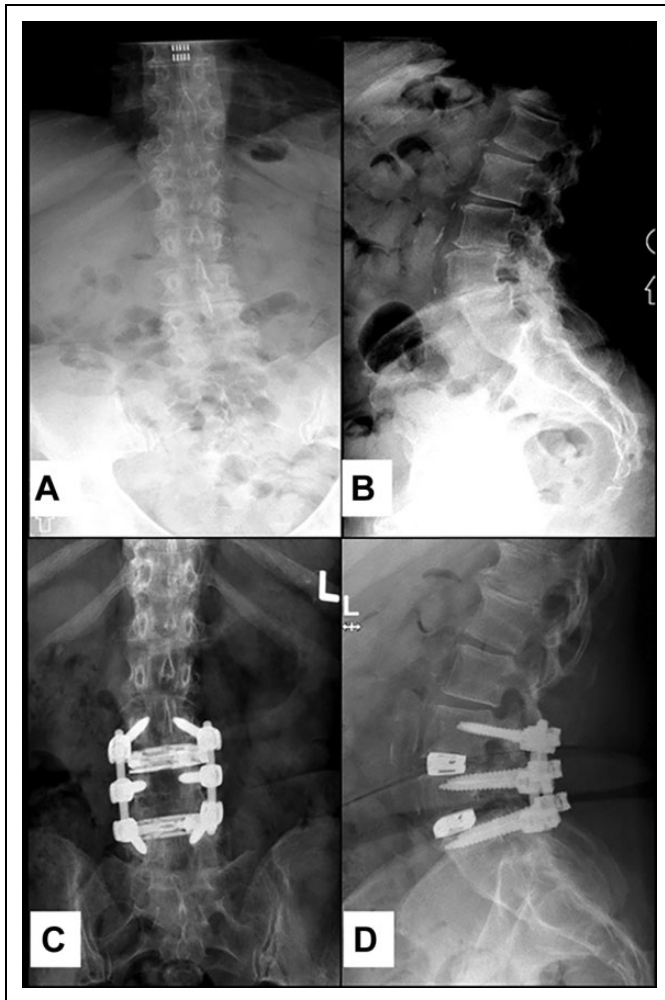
Preoperative (A) anteroposterior (AP) and (B) lateral radiographs and (C) postoperative AP and (D) lateral radiographs of a 2-level MIS LLIF (minimally invasive spine surgery lateral lumbar interbody fusion) at L3/4 and L4/5.
